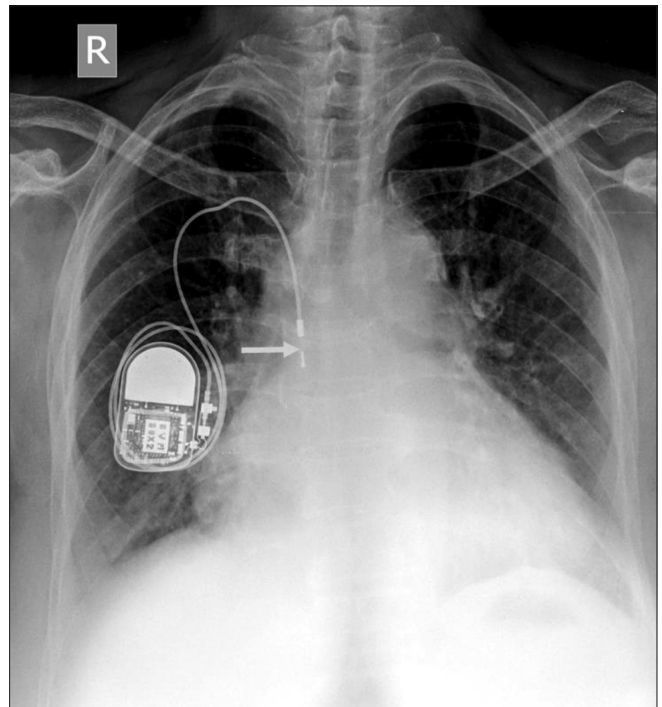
Frontal chest radiograph shows recoil of the pacemaker lead with its tip in the superior vena cava (arrow). This is called Twiddler's syndrome
